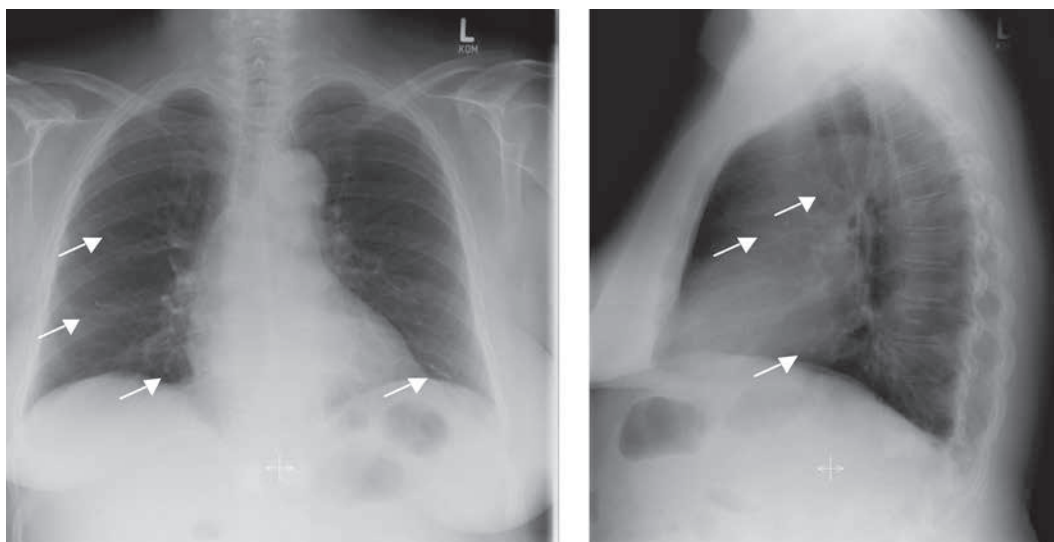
Postoperative AP and lateral plain radiographs of the chest in the single patient with pulmonary cement embolism after balloon kyphoplasty. Numerous radiographically dense tubular branching opacities (arrows) can be seen in both lungs, corresponding to segmental and subsegmental pulmonary vessels.
